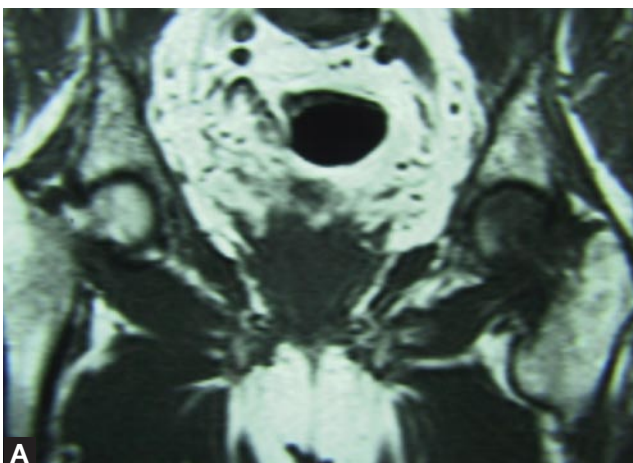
Case 1—(A) T₁-weighted magnetic resonance image of hip shows decreased signal intensity in femoral head and neck suggesting edema. (B) T₂-weighted magnetic resonance image of hip shows increased signal intensity in femoral head and neck suggesting edema.
